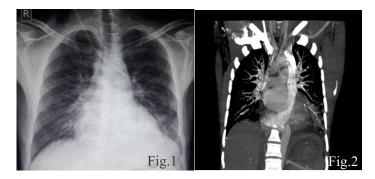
Chest radiography showing right sided non tunnelled haemodialysis catheter
